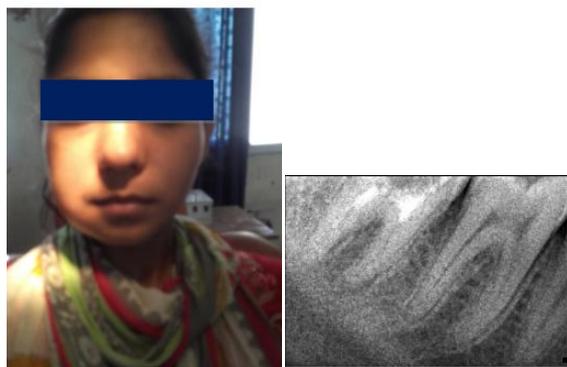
Extraoral swelling and radiograph
